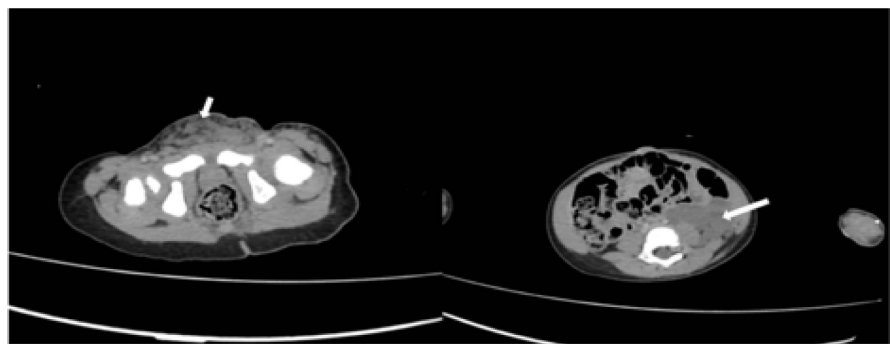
Contrast enhanced axial CT scans of the abdomen and pelvis showing fatty overgrowth of the mons pubis (short arrow) with numerous vessels within. A septated cystic left retroperitoneal mass is seen in the left iliac fossa displacing the descending colon anteriorly (long arrow).
